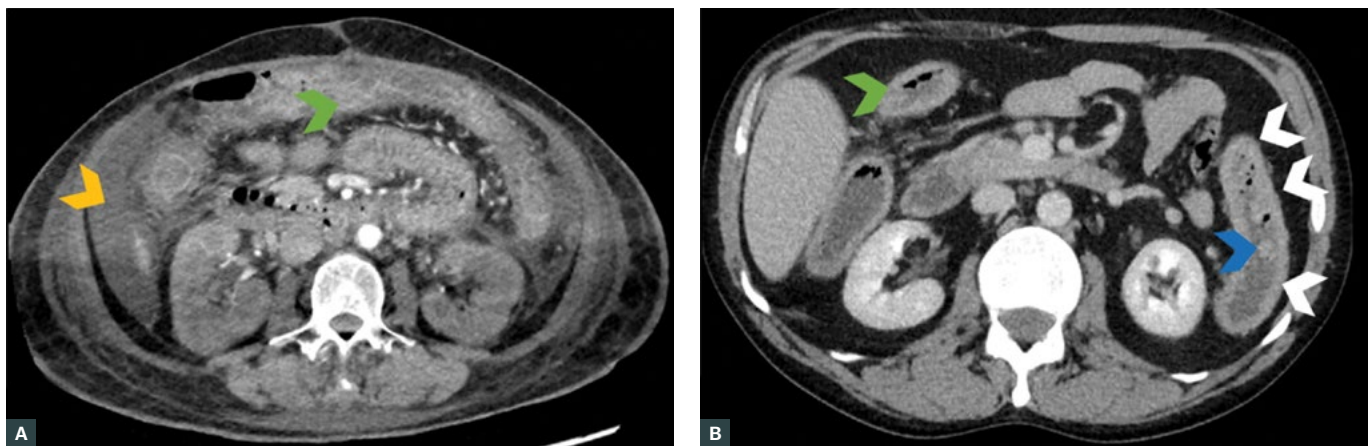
A and B. Axial computed tomography images of acute severe ulcerative colitis patients requiring an operation. These images highlight bowel wall thickening (green arrowhead), loss of haustral markings (white arrowheads), pseudopolyp extending into the lumen (blue arrowhead) and free intraperitoneal fluid (orange arrowhead).
